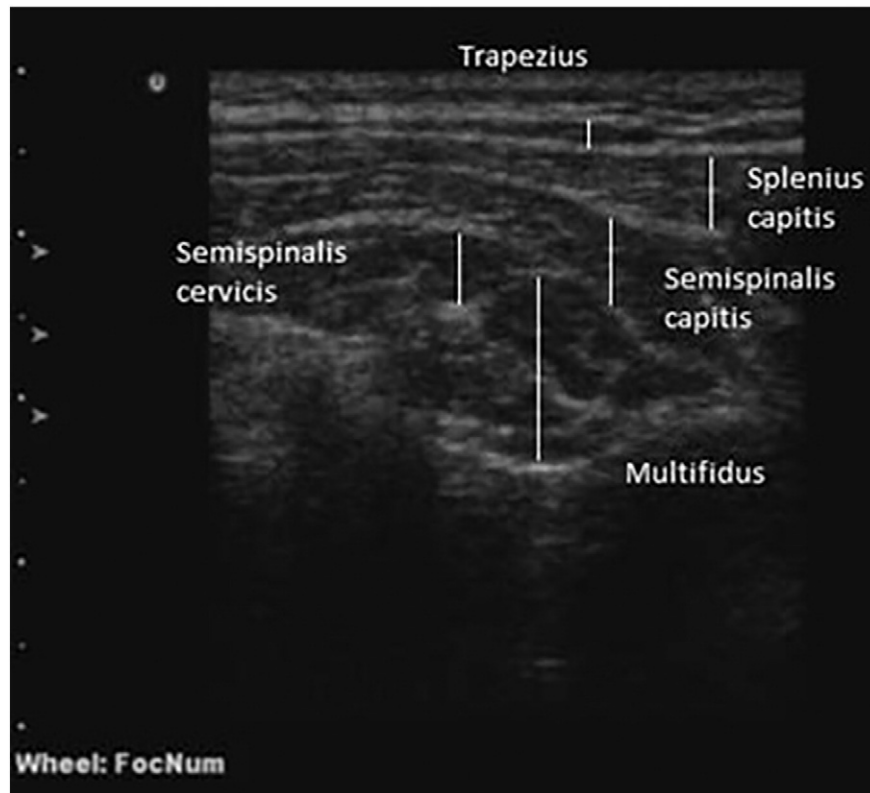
Ultrasonic image of neck extensor muscles. The vertical lines indicate the thicknesses of different muscles.
